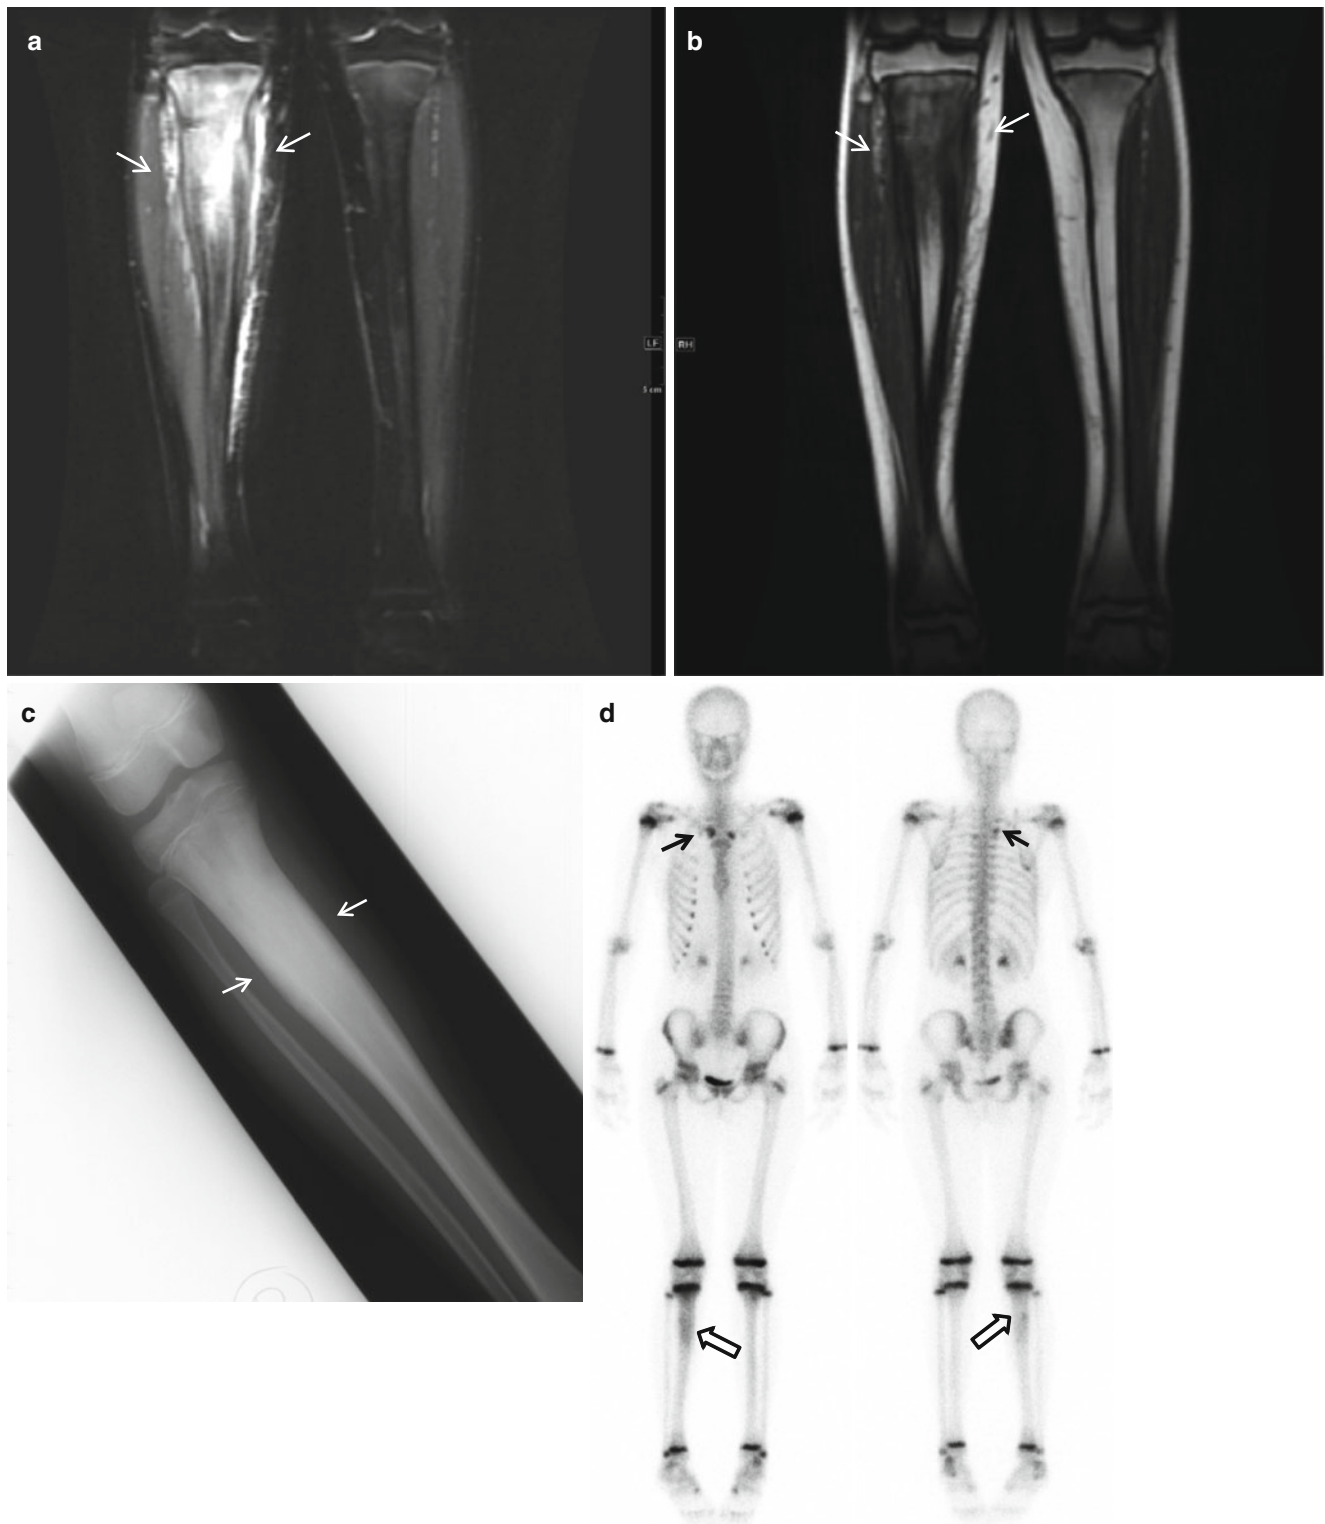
A 12-year-old girl with CRMO. (a, b) Coronal T2-WI with fat suppression (a) and T1-WI (b) demonstrate bone marrow edema with soft tissue swelling (arrows) of the right proximal tibial metaphysis, diaphysis, and metadiaphysis. (c) Follow-up radiograph 2 years after disease onset demonstrates diffuse sclerotic change and cortical
